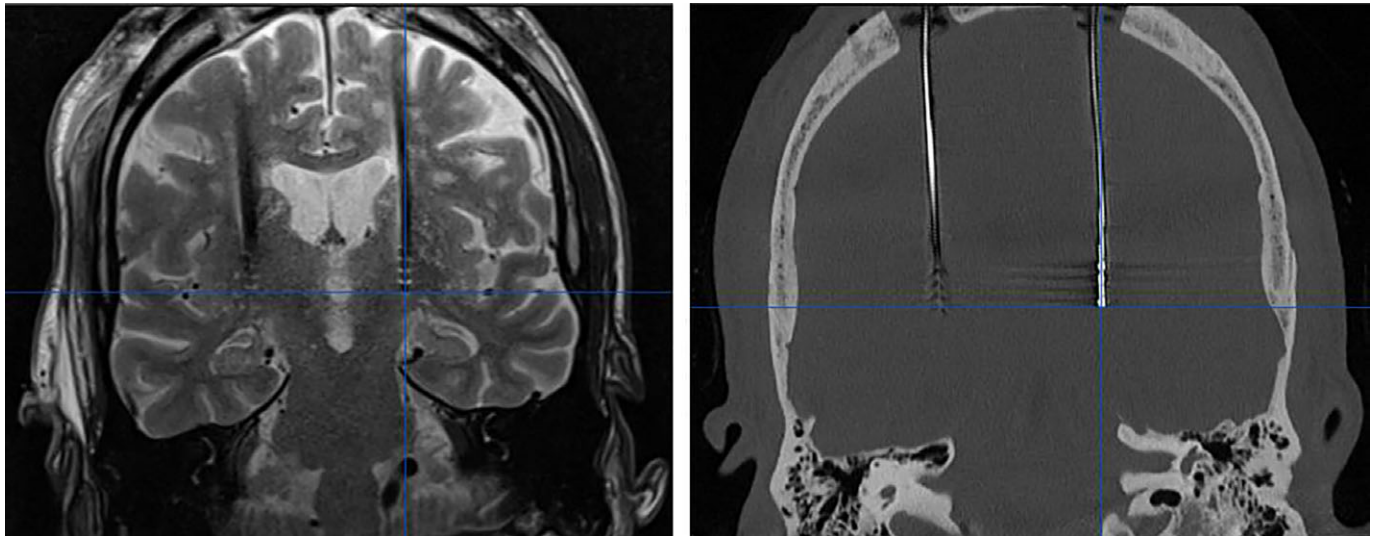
DBS leads of the same patient on MRI (left) and on iCT (before windowing; right). The MRI artifact is depicted as a hypodense signal whereas the CT artifact is hyperdense. [Color figure can be viewed at wileyonlinelibrary.com]
